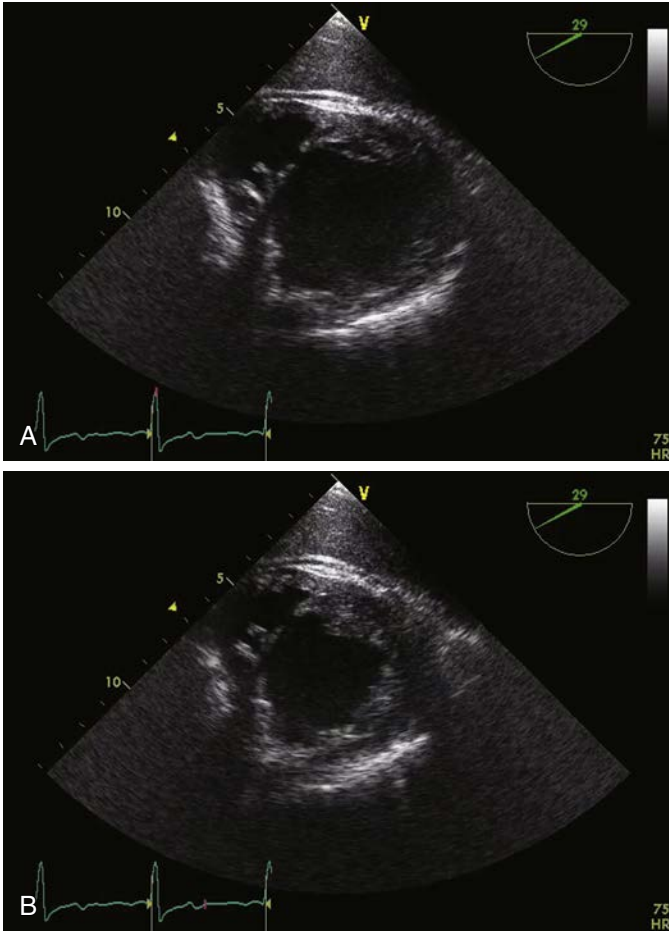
Right ventricular (RV) infarction. Transesophageal echocardiography (TEE) short-axis view at the midpapillary level showing akinesia of the left ventricular (LV) inferoseptal and inferior walls, together with RV inferior wall in diastole (A) and systole (B). A ventricular septal defect also is seen (see Video 31-24). Echocardiographic findings also may include RV regional or global dysfunction, usually with LV inferior wall involvement. Because infarction of the right ventricle sometimes may be manifested only as dysfunction of its inferior wall, attention should be paid to this region, with modified views obtained if needed.
